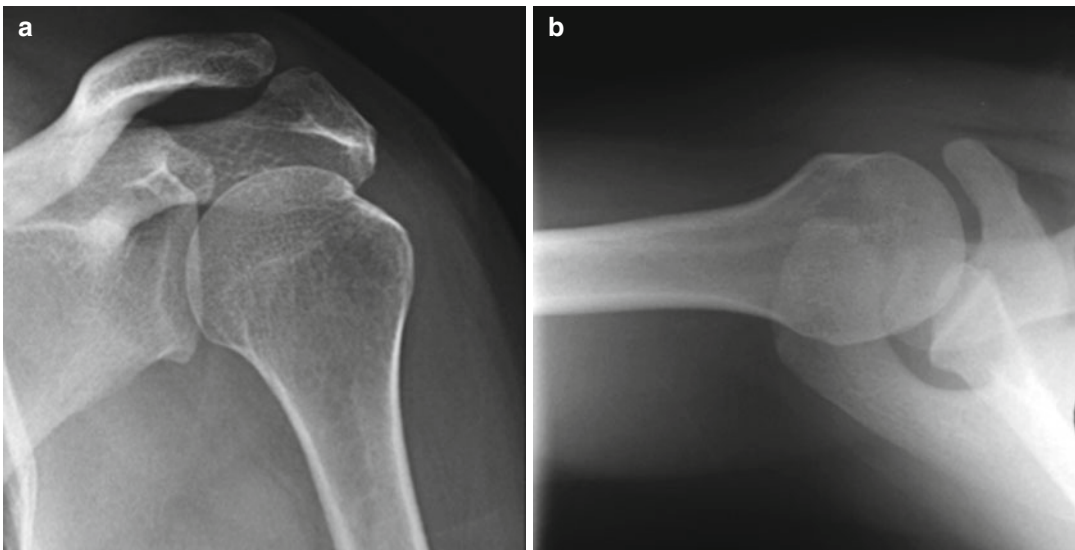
Shoulder X-ray with signs of impingement. (a) Anteroposterior view, (b) axillary view
